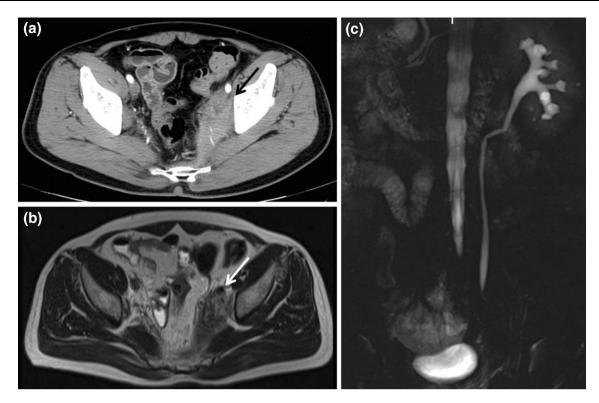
Follow-up CT (a) and MRI (b, c) performed 5 months after surgery show an 11-cm soft tissue mass (*arrows*) involving the left ureter in the left pelvis and left hydronephrosis
